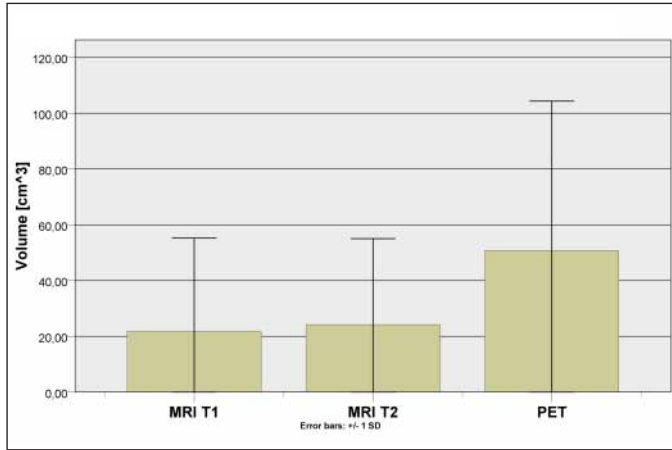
The measured volume of the lesions in T1-MRI, T2-MRI and FDG-PET using the scheme described in the paragraph "Measurement of lesion size".
